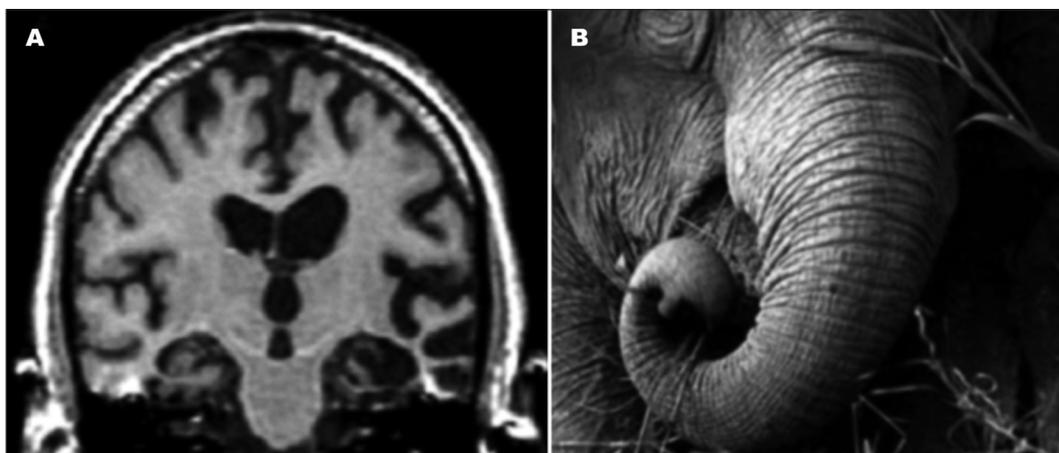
T1-weighted coronal brain MRI showing atrophy at the medial aspects of the temporal lobes and hippocampi. Notice the sulcal exaggeration [A]. The pareidolic aspect of an elephant trunk has been referred to as the elephant sign [B].
